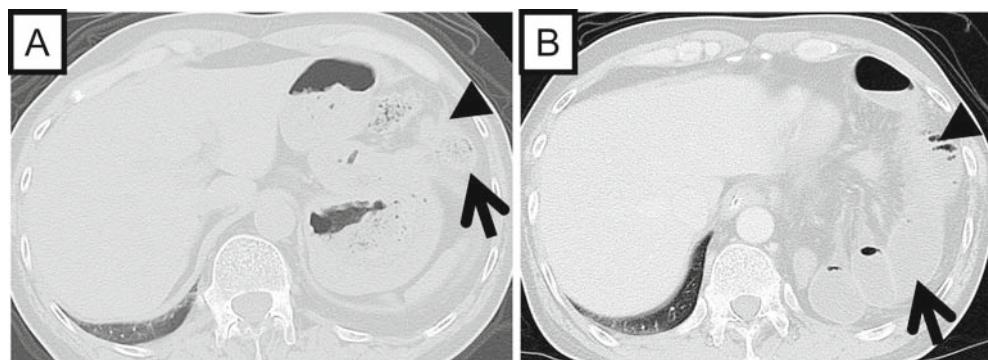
A Computed tomography scan shows a defect in the left diaphragm (arrowhead), the mesentery, and large intestine in the left thoracic cavity (arrow). B The large intestine (arrowhead) and the fluid-filled small intestine (arrow) have herniated into the left thoracic cavity
